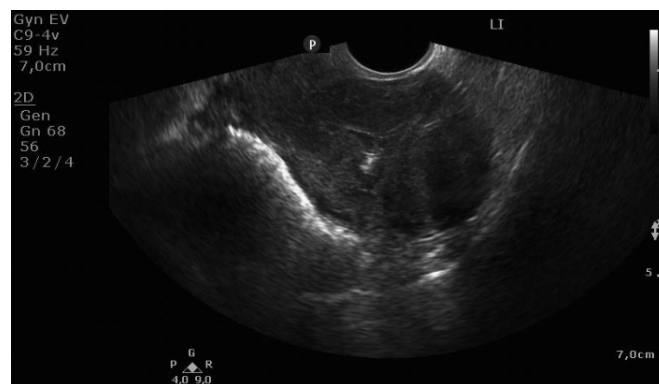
Transvaginal ultrasound 2 months after hysteroscopic resection of the fibroid which was expelled into the uterine cavity after treatment with the Sonata system.
